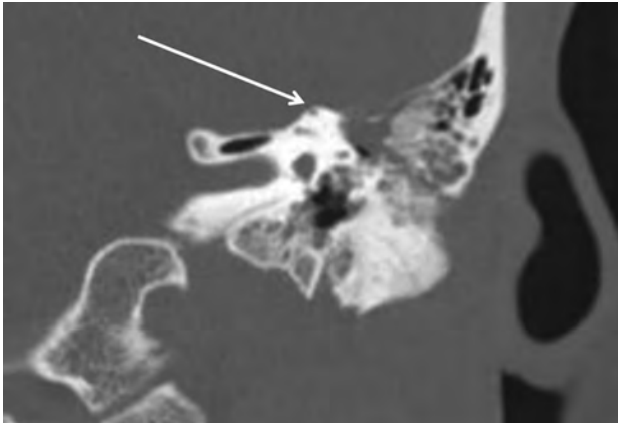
Dehiscent superior semicircular canal. Coronally reformatted CT of the temporal bone demonstrates dehiscence of the roof of the superior semicircular canal (*arrow*).
